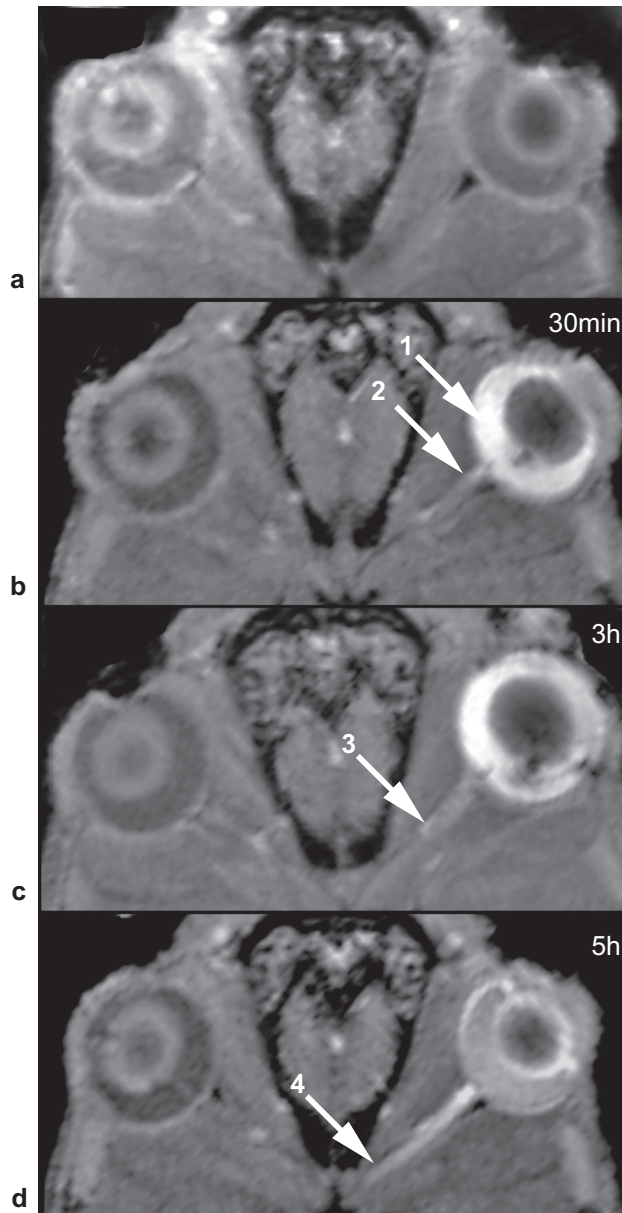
MRI of left eye and ON before (a) and 30min (b), 3h (c) and 5h (d) after intravitreal injection of $3\mu\text{l}$ 50nM MnCl_2 . The enhancement in the vitreous body (1) gradually decreased as Mn^{2+} enhancement increased along the ON (2-4).
